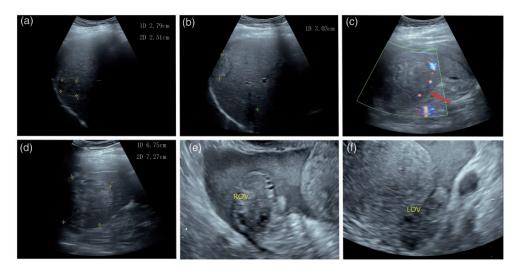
(a, b) Ultrasound of the liver showing liver lesions before emergency surgery. (c, d) Ultrasound of the spleen showing a spleen lesion before emergency surgery (arrow). (e, f) Ultrasound of the ovary showing no abnormalities before emergency surgery.
